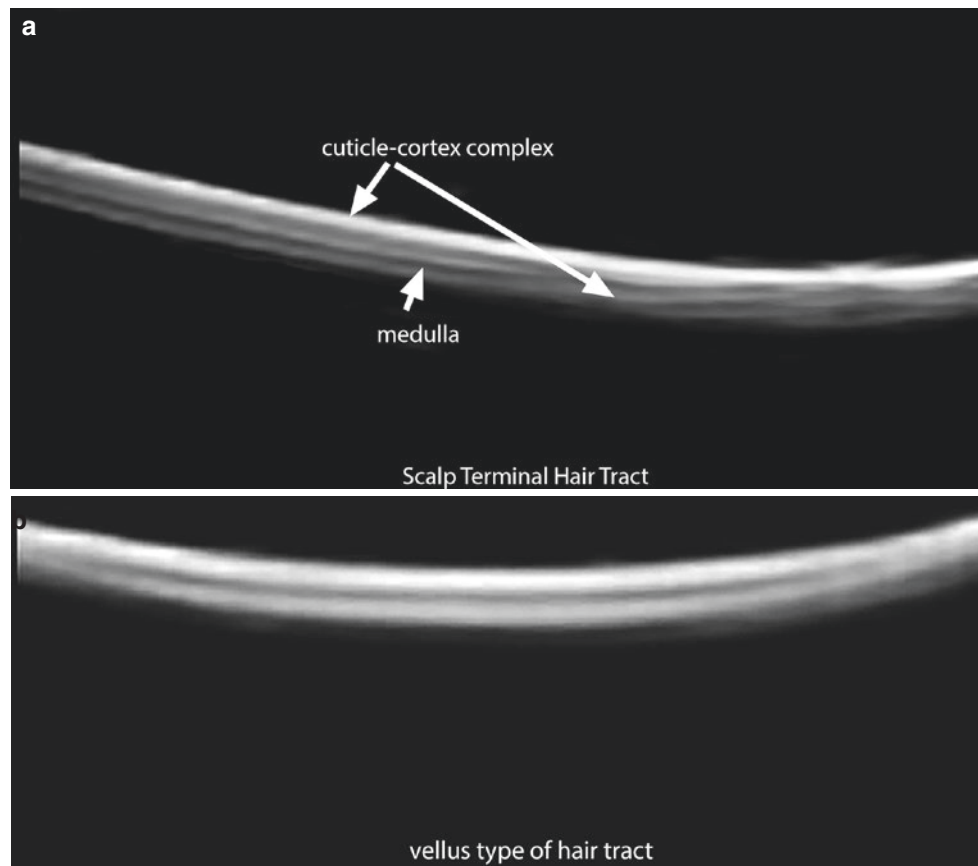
Normal ultrasound morphology of the hair tracts. (a) Trilaminar terminal hair tract of the scalp. (b) Bilaminar or vellus type of hair without medulla most commonly found in the rest of the body.
